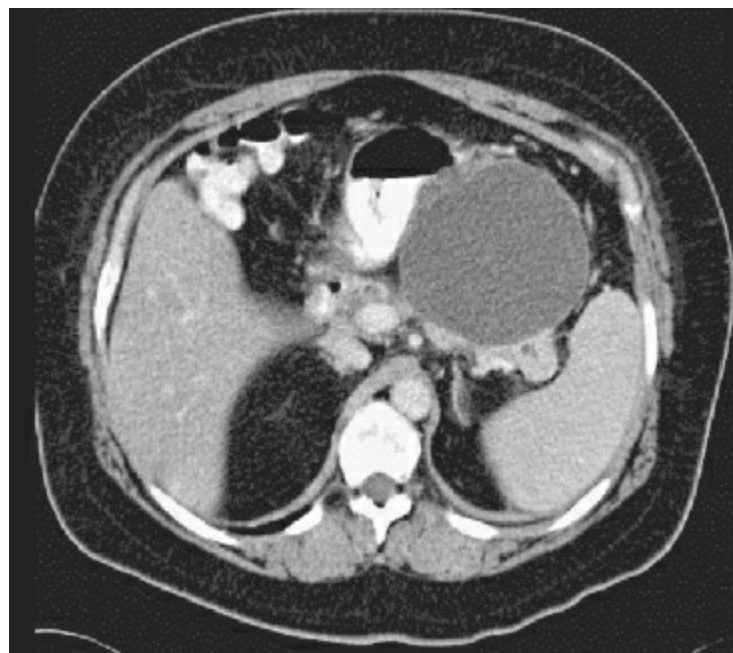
Computed tomography scan of pancreatic pseudocyst.
